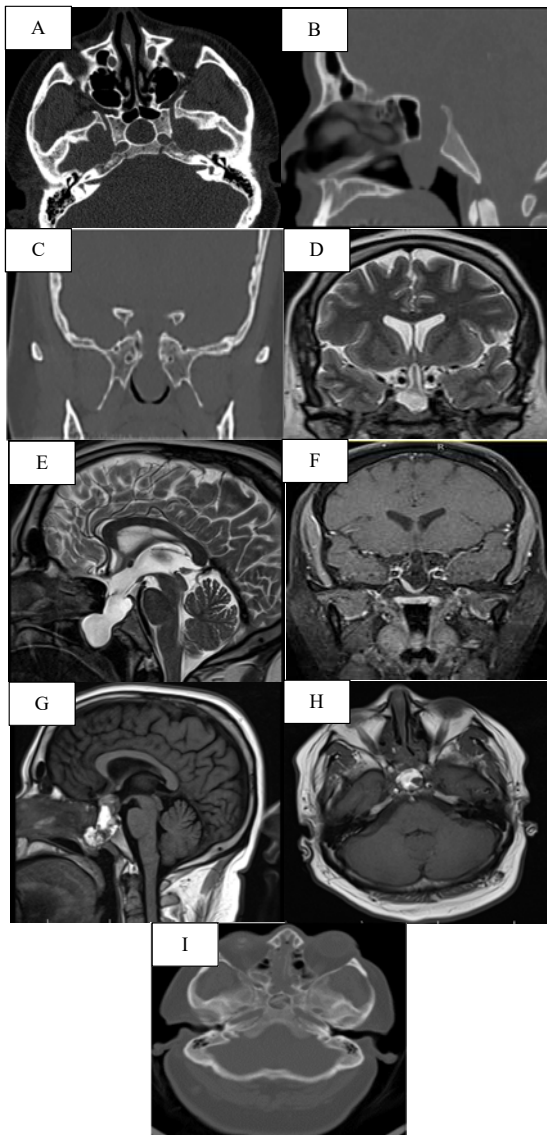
A, B, C: Preoperative axial, sagittal, and coronal computed tomography (CT) scan revealed a skull base defect with cortical bone formation around the hole, D and E: preoperative coronal and sagittal T2-weighted magnetic resonance imaging (MRI) presented the herniated meningoencephalocele (MEC) into the sphenoid sinus and nasopharynx. F: preoperative dynamic coronal view of pituitary gland displaced in the right side into the sphenoid sinus. G, H: postoperative sagittal and axial T1 MRI presenting the basal defect reconstruction. I: postoperative axial bone window view showing the reconstructed basal defect with nasal septum bone. A': endoscopic view of nasopharyngeal part of MEC, B' and C': central corridor exposure with subperiosteal dissection in the left and right sides. D': bipolar coagulation of MEC to shrink the cyst. E': MEC opening to drain the CSF and continuing dissection all around the cyst wall. F': pushed up MEC. G': reconstructed basal defect using fat and septal bone
